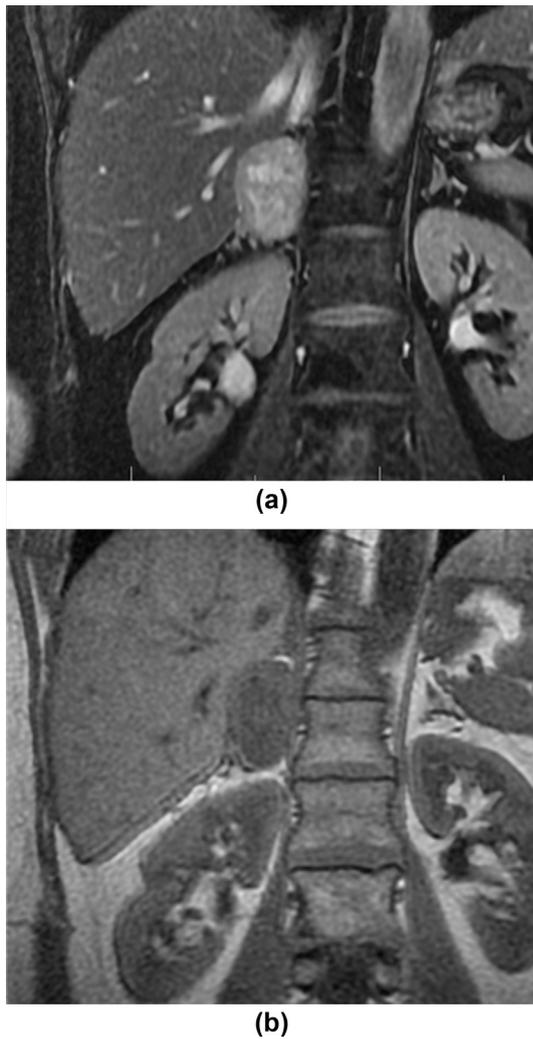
(a) Coronal T2-weighted MRI appearance of a right-sided pheochromocytoma. The mass is arising from the adrenal gland and has high to intermediate T2 signal. (b) The corresponding in-phase T1 image demonstrates intermediate T1 signal.
